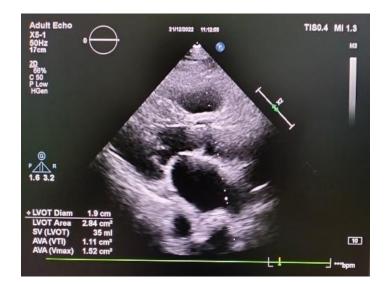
Measurement of LVOT diameter on the parasternal long axis gives the LVOT cross-sectional area of 2.84 cm. Through calculations using the continuity equation, the cross-sectional area of the ascending aorta is obtained. experiencing obstruction 1.52 cm 2
